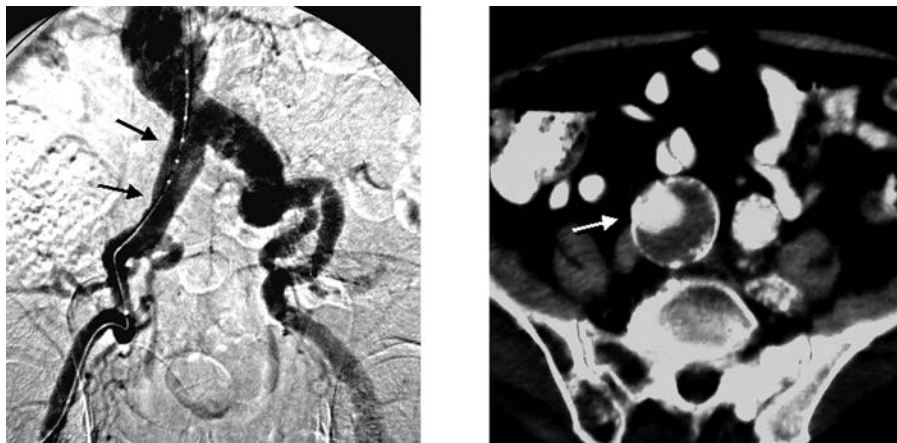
(Left) This aortogram shows the arteriographic marker catheter traversing the right common iliac artery (*black arrows*), which looks generally more dilated than normal but not strikingly so. (Right) The true dimensions of this patient’s thrombus-filled right common iliac aneurysm (*white arrow*) are shown on a representative slice of a contemporaneous CT scan.
